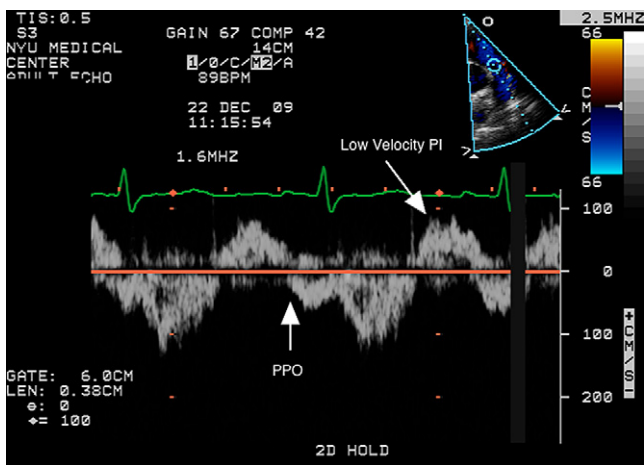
Pulsed-wave Doppler obtained by transthoracic imaging at the pulmonic valve demonstrates low-velocity nonturbulent PI and premature pulmonic valve opening (PPO).
